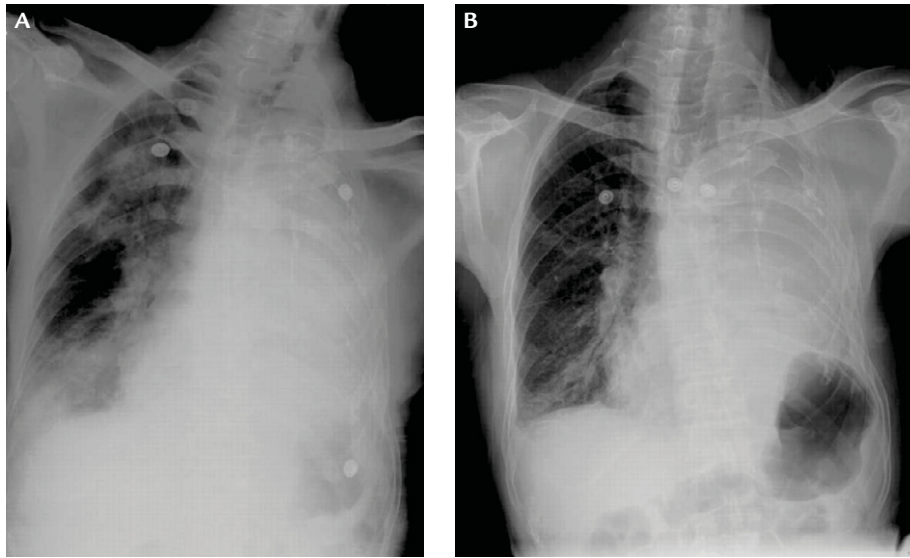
Chest radiographs of high altitude pulmonary edema: (A) before treatment; (B) 3 days following the use of diuretics.
